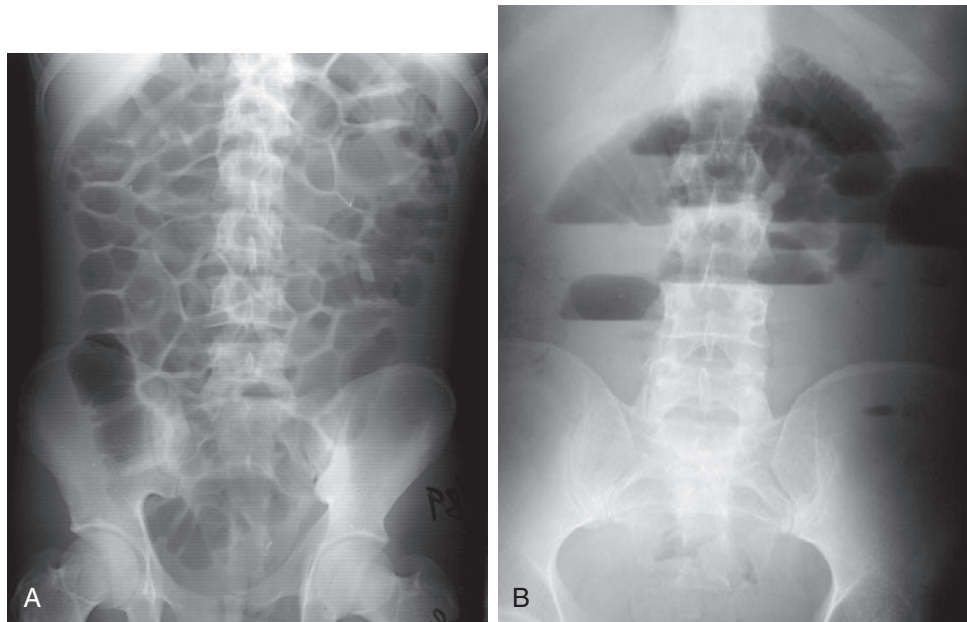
■ (A) Ileus. Abdominal radiograph shows multiple air-filled dilated loops of small bowel as well as an air-filled colon and rectum. (B) Small bowel obstruction. Abdominal radiograph shows dilated loops of small bowel and multiple air/fluid levels. Small bowel has a paucity of gas and no evidence of air within the colon.
